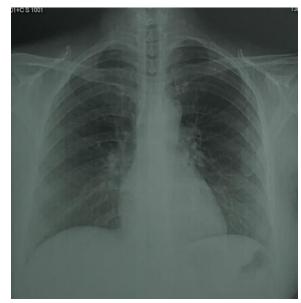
Frontal chest X-ray: normal
